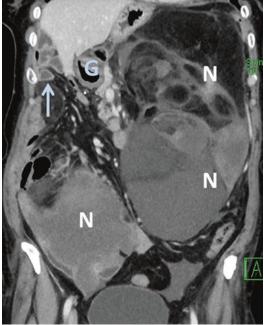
Contrast-enhanced CT coronal image in venous phase displays significant enhancement of the solid component with a clear and smooth boundary from the adjacent structure. Multiple abnormal mass-like lesions (N) occupy the entire left abdominal cavity and the right lower quadrant area, while the gastric body, small intestine and mesentery $(\ \ \)$ are seen only in the right upper quadrant. There is a small amount of ascites in the left-inferior abdominal cavity
